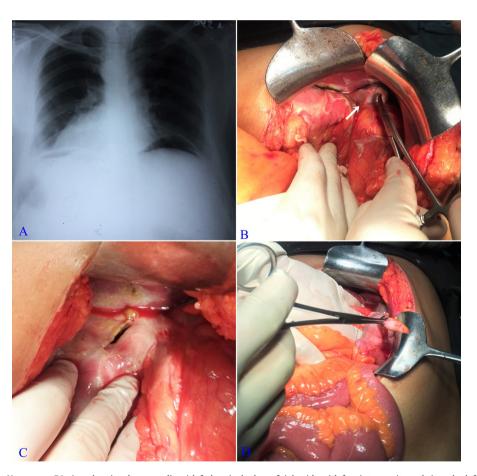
in Patient 1 (A) Chest X-ray erect PA view showing dextrocardia with fudus air shadow of right side with free intra-peritoneal air under left hemidiaphragm. (B) Liver and gall bladder (white arrow) on the left side. (C) A 2.5 cm × 0.5 cm antral perforation on anterior wall of stomach. (D) Appendix on left side.
